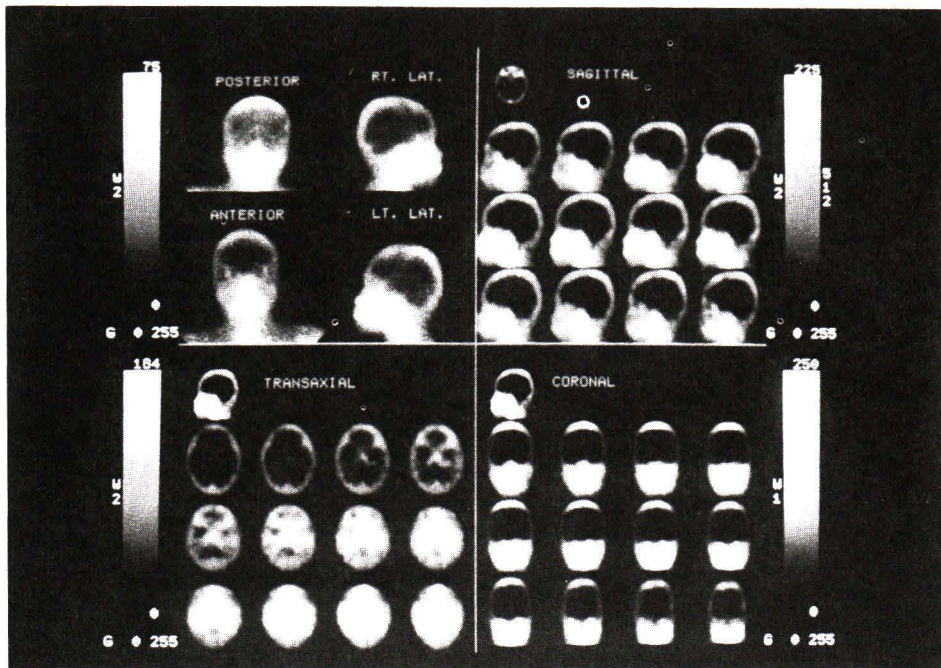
Planar and SPECT images at skull showed negative study in a craniopharyngioma patient.
